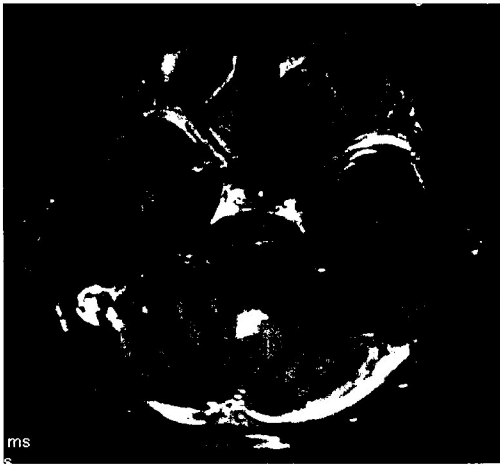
Postoperative T1-weighted brain MRI images with gadolinium enhancement show postoperative changes within the fourth ventricle (i.e., intense periventricular increased signal). However, there is no evidence of recurrent tumor within the posterior fossa.
